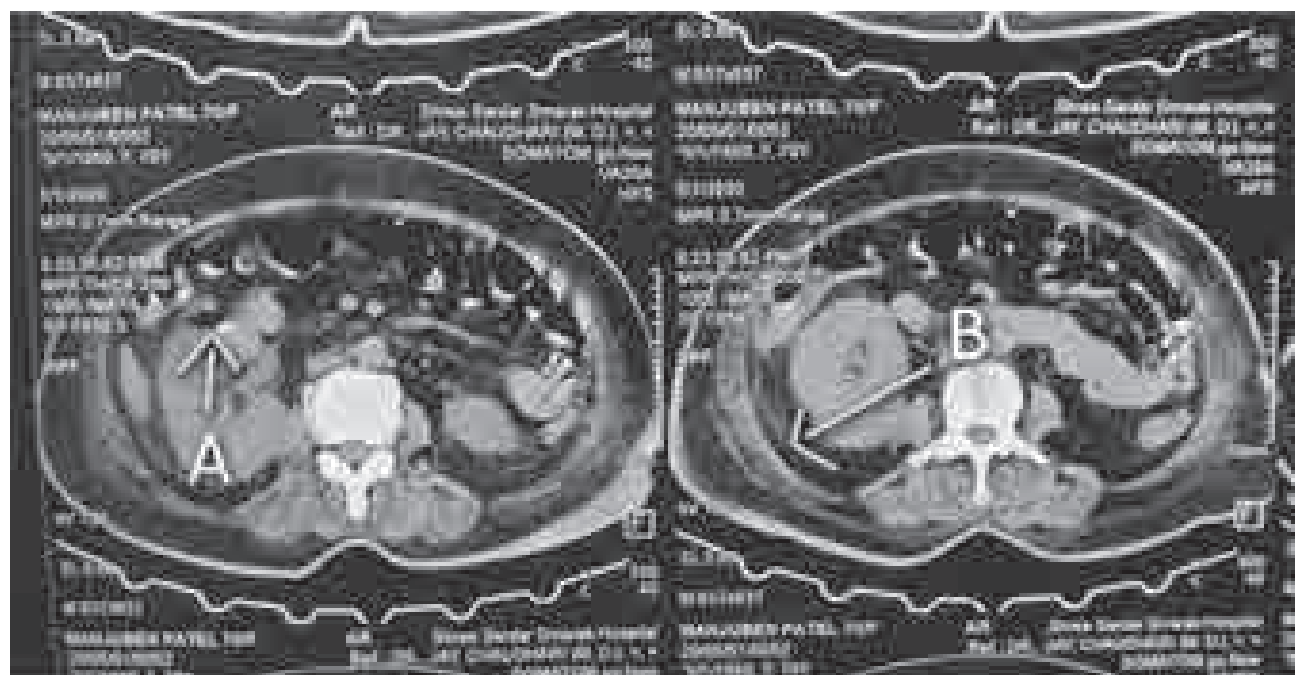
CT KUB Plain showing A- Air foci in anterior aspect of right kidney and B- Perinephric fat strand suggestive of emphysematous pyelonephritis.
